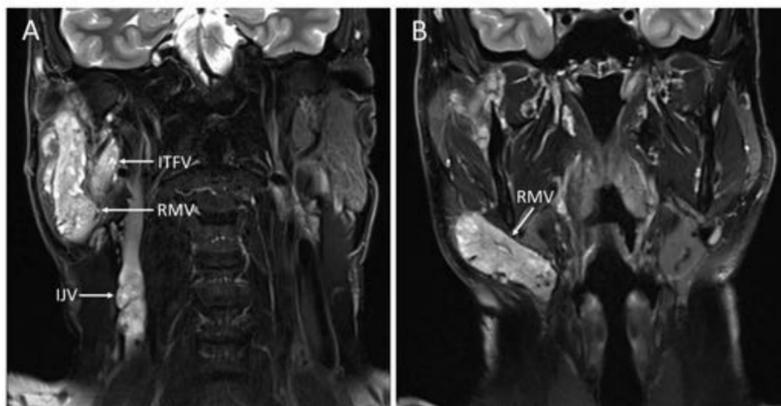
T₂ coronal MRI scan through the parotid gland (A) and more anteriorly (B)
